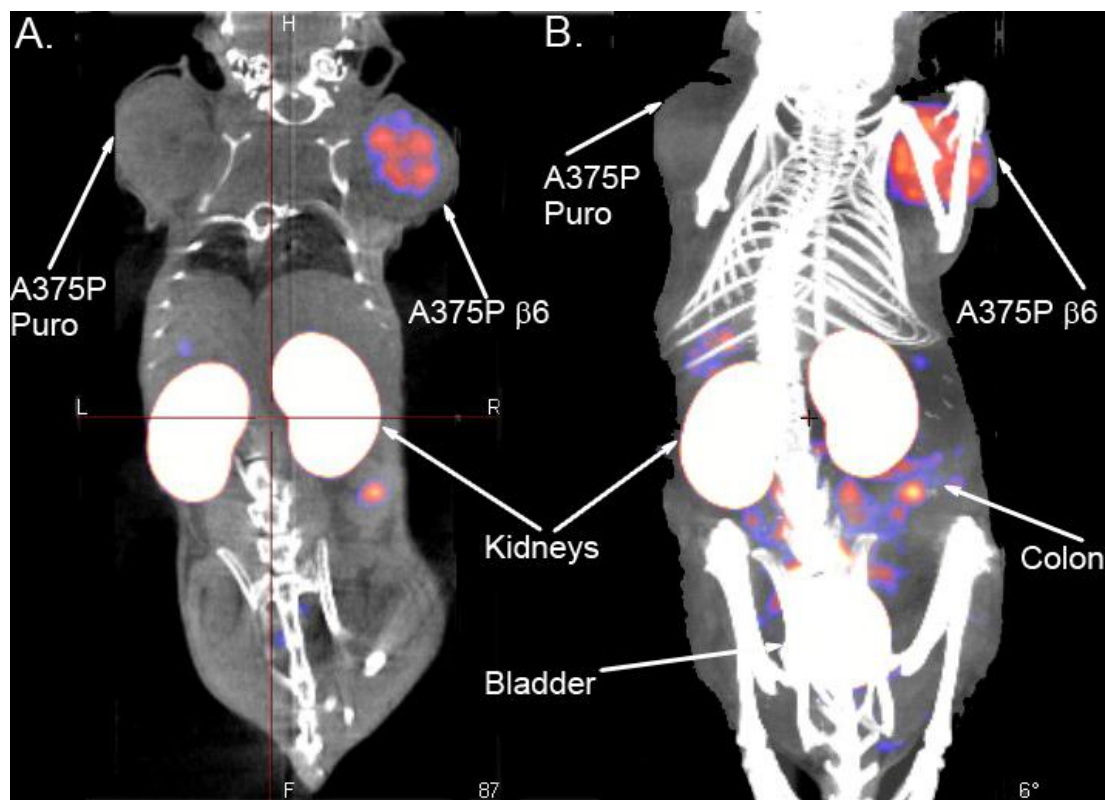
NanoSPECT/CT imaging of $\alpha v \beta 6$ -expressing tumour with ^{111}In -DOTA-A20FMDV2:
